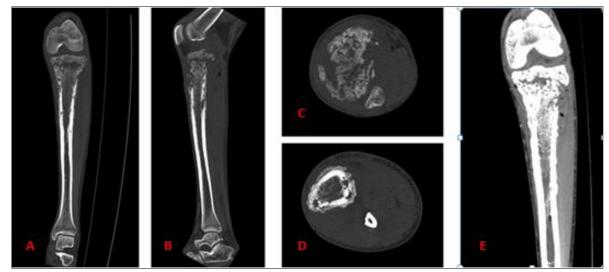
CT scan of the right leg in coronal (A), sagittal (B), and axial (C and D) slices using bone window, and coronal slice (E) using soft tissue window, demonstrating a moth-eaten osteolytic process involving the epiphysis, metaphysis, and proximal diaphysis of the right tibia. The lesion extends into the bone marrow and contains multiple fat globules. Cortical remodeling with breaches is noted, along with dense intralesional bone fragments corresponding to bone sequestra
